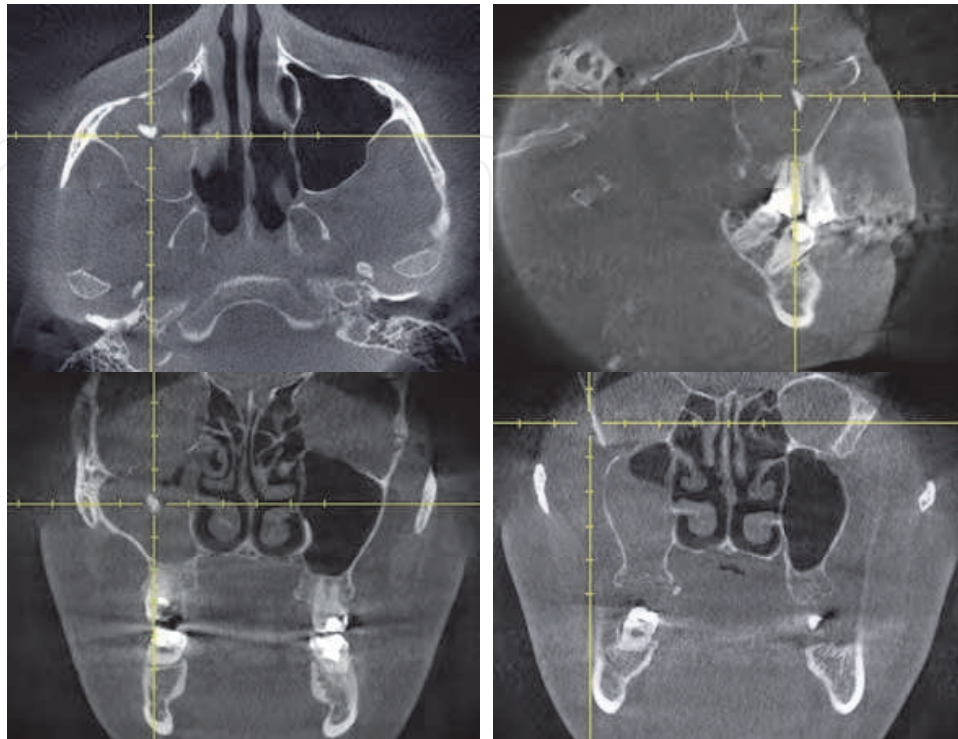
Cone-beam CT of a patient with OAF and a root tip pushed into the sinus. Such situation is usually followed by pronounced inflammatory reaction.
